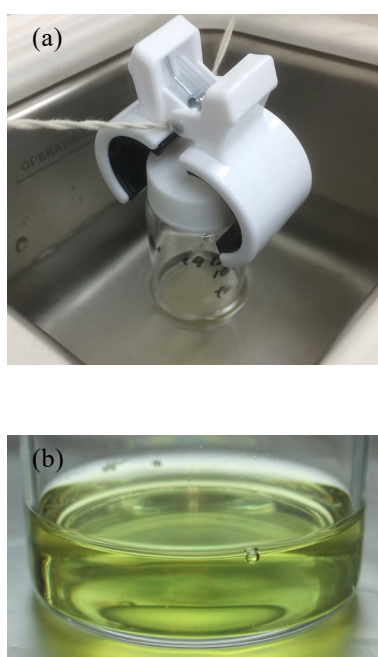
Ultrasonic-enzymatic digestion (a) and lung digestion solution (b)
